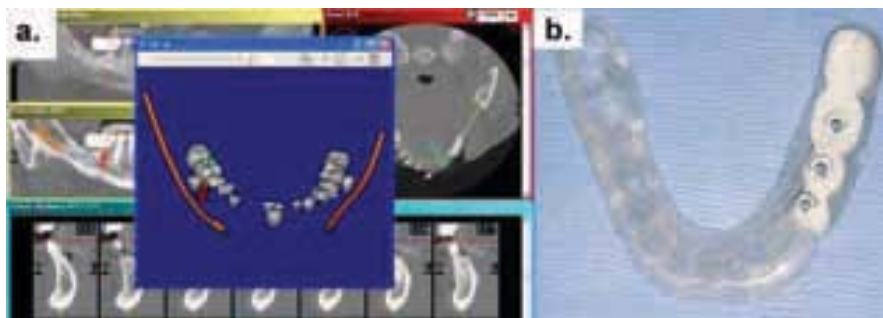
Virtual implant placement and surgical guidance using CBCT: (a.) Screen of implant placement software (VIP, Implant Logic Systems, Cedarhurst, NY) with multiple projections relating prosthetic placement of teeth with important anatomic structures, and locating implants in 3D and (b.) Surgical guidance stent for implant placement manufactured from planning performed using VIP software. (Courtesy of Dr Michael Klein, Implant Logic Systems, Cedarhurst, NY).
